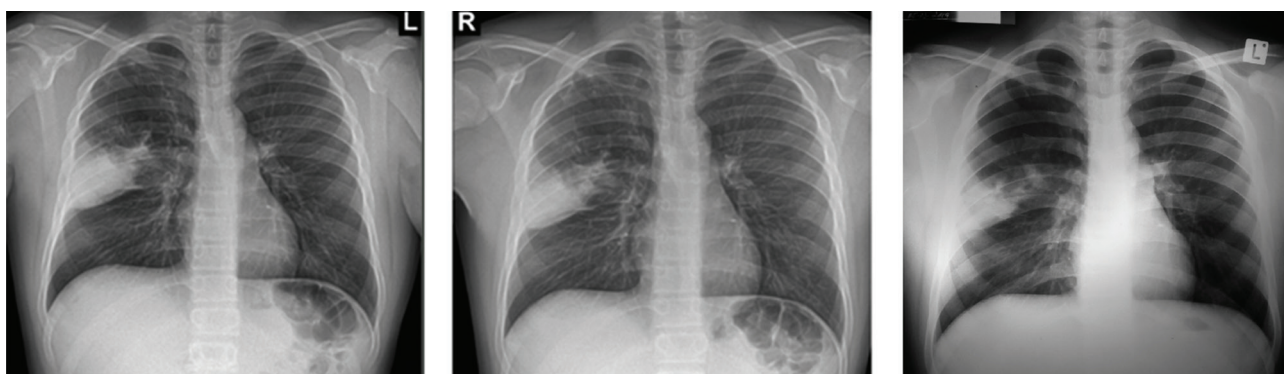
Chest X-ray: right-sided pneumonic infiltrates and hyperinflation of the right upper lobe.
